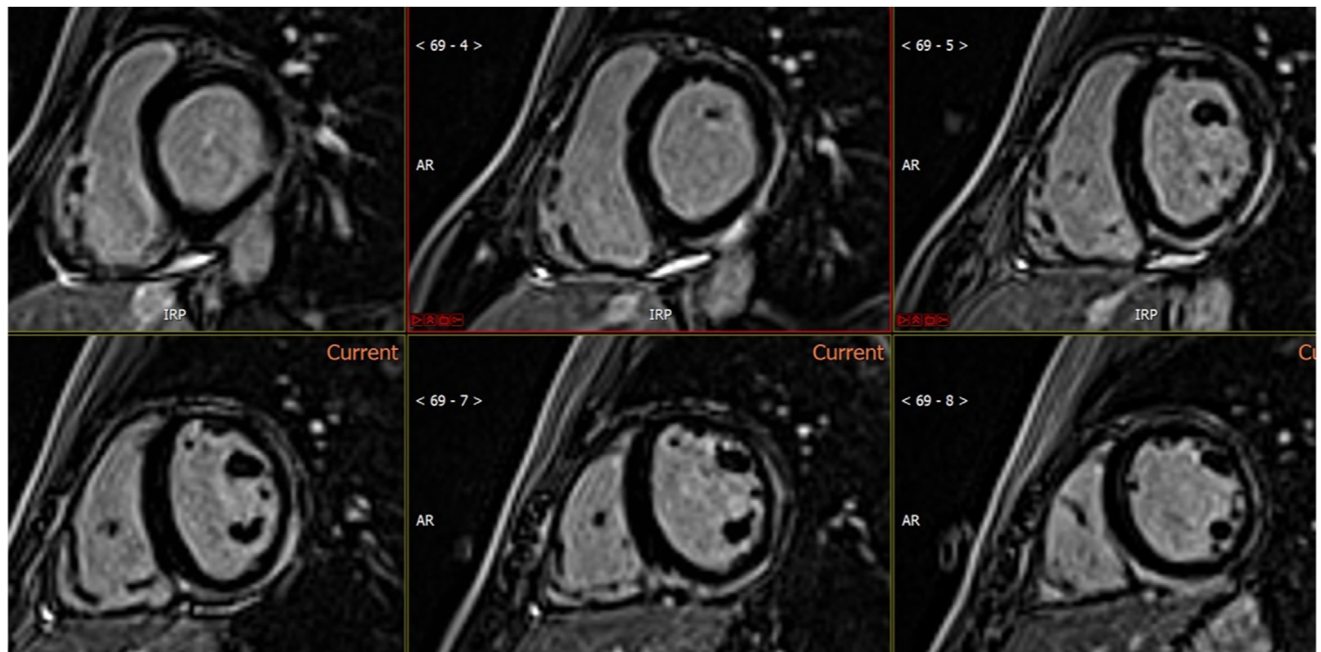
Cardiac magnetic resonance imaging showing epicardial enhancement involving the basal inferior and inferolateral walls, suggesting myocardial fibrosis due to nonischemic etiologies.
